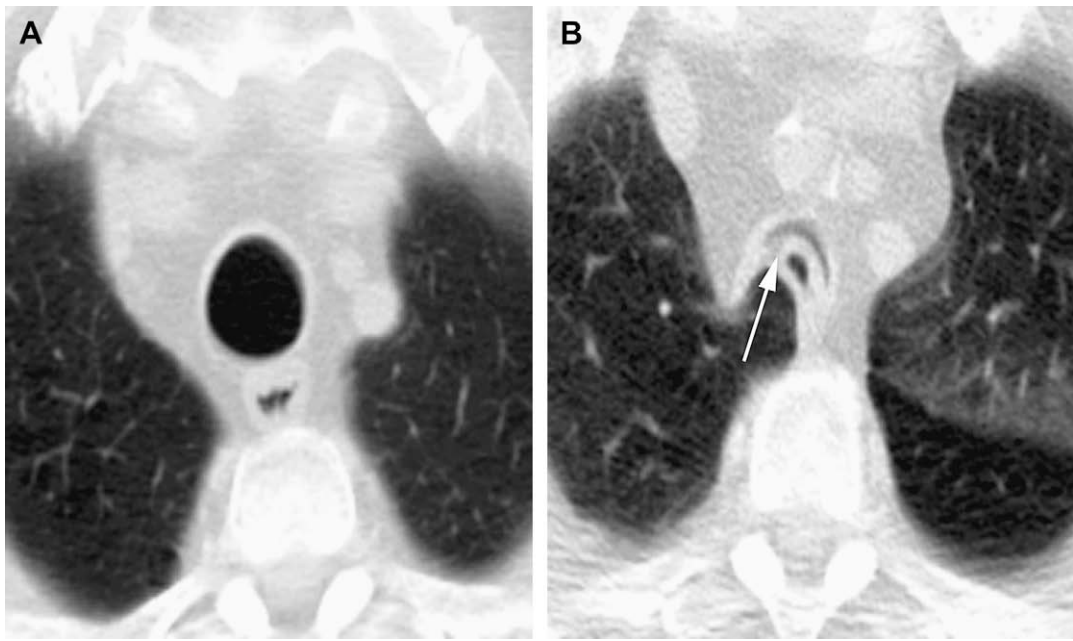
CT diagnosis of TM in a 72-year-old man with shortness of breath. Paired inspiratory CT image (A) demonstrates a normal oval shape of the tracheal lumen. Dynamic expiratory CT image (B) shows excessive expiratory collapse of the trachea (arrow) consistent with TM.
